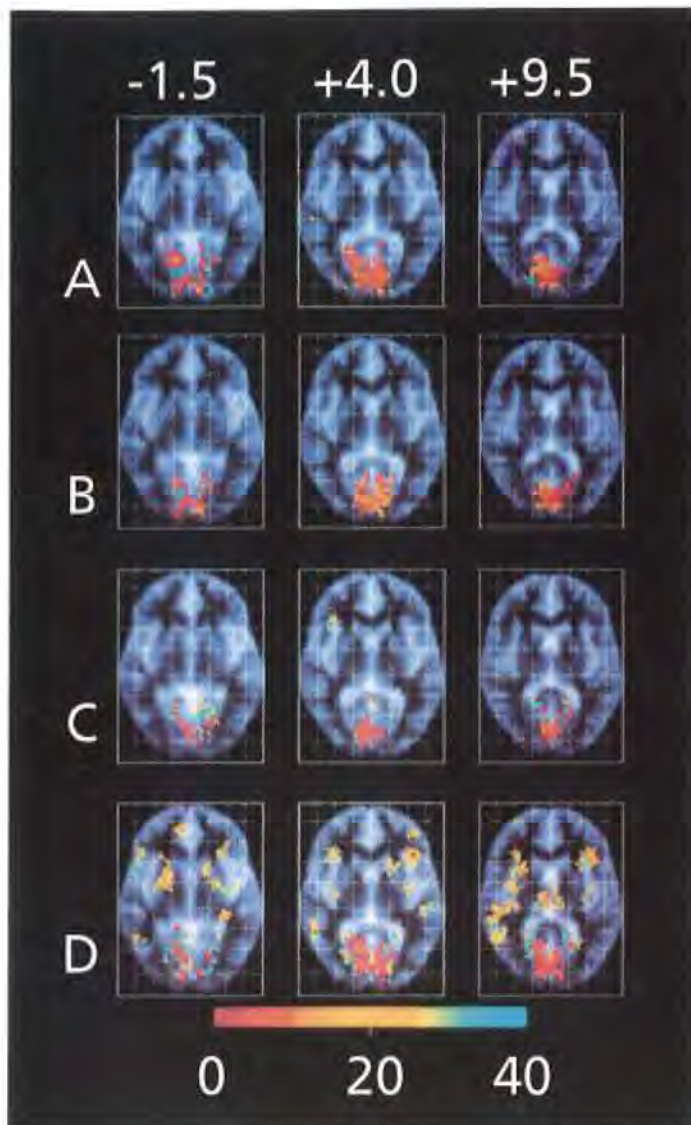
Functional MRI elicited response from monocular visual stimulation in healthy controls. (A) Left eye, (B) right eye, (C) patients with previous unilateral optic neuritis when stimulating the clinically unaffected eye and (D) affected eye. In healthy individuals, activation is largely confined to the primary visual cortex. Extrastriate activation is most apparent after stimulating the affected eye of patients. From Werring *et al* (2000b) with permission.
